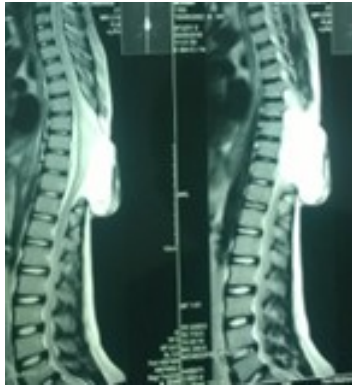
MRI of dorsal spine (sagittal views) showing dorsal meningocele. Source: Figure by authors.
